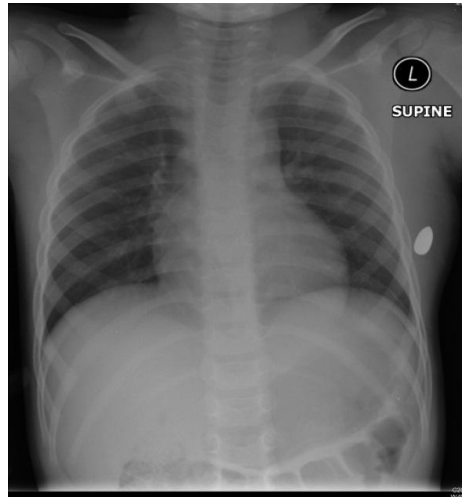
Chest X-ray, the site of the bullet is outside the chest cage at the left chest wall
